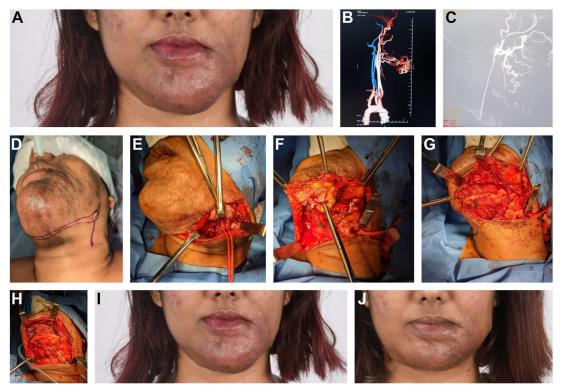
Case 6: (*A*) High-flow vascular malformation involving chin and lip. (*B*) computed tomography (CT) angiogram showed multiple feeders from branches of the external carotid artery (ECA). No intra-osseous extension of the vascular channels noted. (*C*) Embolization of multiple vascular feeding channels was done with polyvinyl alcohol (PVA) particles. (*D*) Surgical incision marking 2 days post embolization. (*E*) Exposure of carotid control prior to debulking and wide excision of the subcutaneous vascular lesion. (*F*) Exposure of external carotid artery and control prior to debulking and wide excision of the subcutaneous vascular lesion. (*G*) Excision and corseting of residual lesion. (*H*) Completion of excision and debulking of the vascular lesion. Case 6: (*I*) Preoperative lip and chin area vascular lesion. (*J*) Postsurgical excision of the facial subunit regions with ongoing laser therapy for pigment reduction caused by vascular lesion of the subcutaneous areas.
